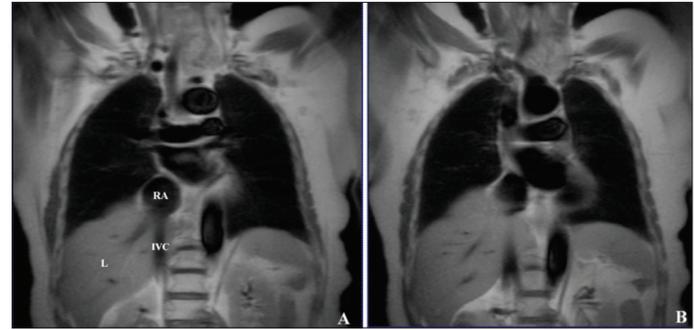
Magnetic resonance imaging coronal views of displaced liver due to the right-sided diaphragmatic elevation, with compression of the IVC and its entrance to RA
